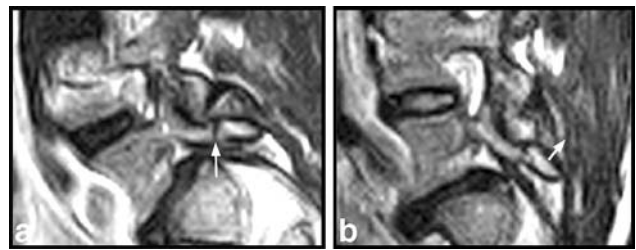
Postoperative recurrent fluid disc herniation 8 months following partial right-sided discectomy in a patient with recurrent signs and symptoms. a Recumbent midline sagittal T2-weighted fast spin echo MRI (rMRI) shows a flat posterior surface (arrow) of the L5–S1 intervertebral disc. b Upright-neutral midline sagittal T2-weighted fast spin echo MRI (pMRI) reveals a focal posterior disc herniation extending from the L5–S1 intervertebral disc space. Note the tenting of the posterior longitudinal ligament and the thecal sac (arrowheads) secondary to the mass effect of the epidural disc herniation. c Upright-neutral midline sagittal T1-weighted fast spin echo MRI (pMRI) shows a poorly defined mass (arrow) extending posteriorly from the L5–S1 disc space. d Upright-neutral midline sagittal T1-weighted fast spin echo MRI (pMRI) following the intravenous administration of gadolinium demonstrates peripheral rim enhancement surrounding the centrally nonenhancing recurrent disc herniation (arrow). Also again note the tenting of the posterior longitudinal ligament and dura mater (arrowheads) secondary to the mass effect of the epidural disc herniation. (Case courtesy of M. Rose).
